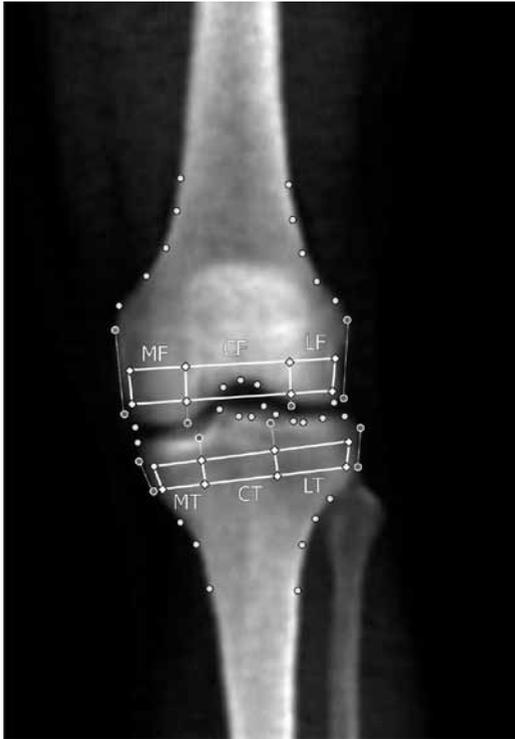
Determination of 6 regions of interest (ROIs) by using landmark points. MT, medial tibia; CT, central tibia; LT, lateral tibia; MF, medial femur; CF, central femur; LF, lateral femur.
